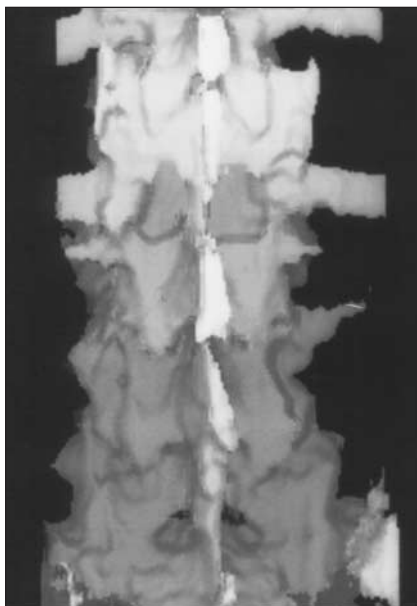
Computed tomography coronal reconstruction demonstrating a split in the L3 spinous process and pars interarticularis.
